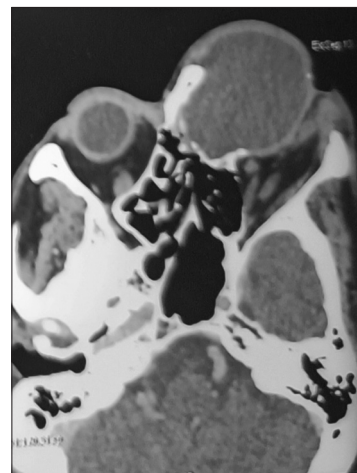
CT scan of the paranasal sinus showing left side frontoethmoidal mucocele with proptosis of the left eye. CT: Computed tomography
